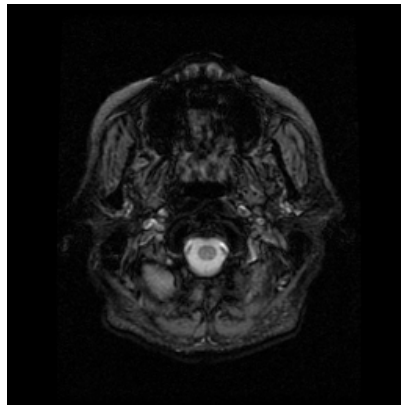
MR image with identified masseter regions.
